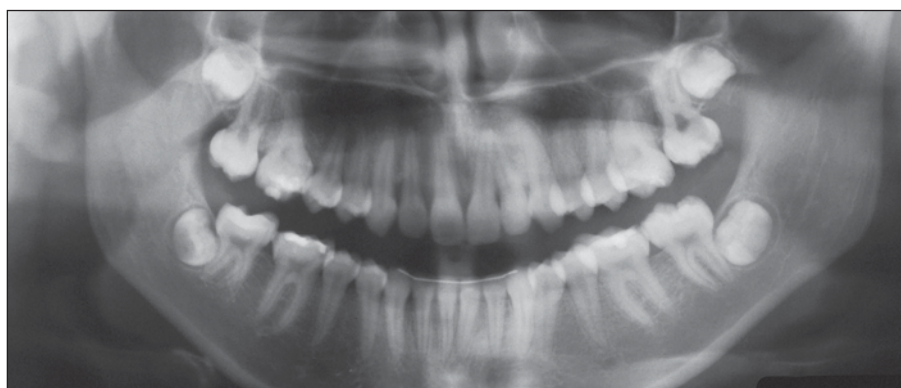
Patient PM, 14 years of age. Posttreatment panoramic radiograph.
